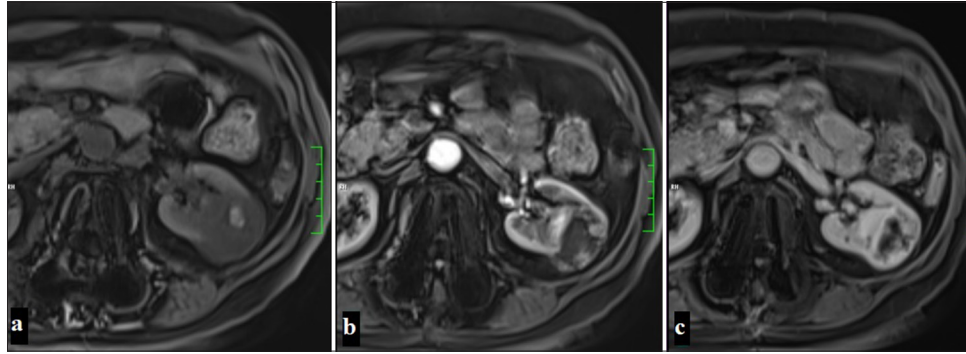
A 60-year-old woman with a lesion observed as hypointense compared to the renal parenchyma in precontrast fat-suppressed T1-weighted imaging, containing a hyperintense area suggestive of focal hemorrhage. The mass shows contrast enhancement except for the central cystic areas in the corticomedullary phase and nephrogenic phase on dynamic MR examination, displayed sequentially in the images (Clear cell renal cell carcinoma).
